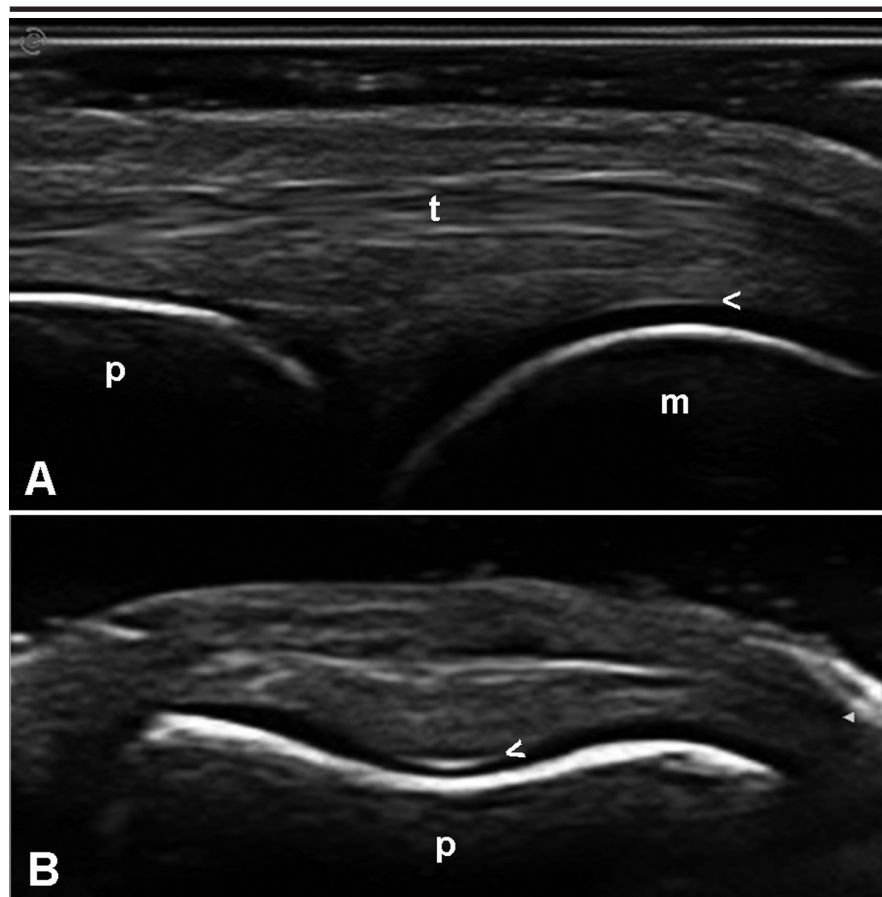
Healthy subject. High-resolution grey-scale ultrasound using a 18 MHz linear probe showing anatomic details less than 1 mm in size. A. Longitudinal dorsal view of the metacarpophalangeal joint in maximal flexion visualizing a subtle anechoic layer of 0.4 mm covering the metacarpal head. B. Transverse dorsal view of the head of the proximal phalanx. The hyaline cartilage is 0.12 mm thick. The arrowheads indicate the chondro-synovial interface appearing as a thin hyperechoic line at the areas of the cartilage surface perpendicular to the ultrasound beam direction. m = metacarpal head; p = proximal phalanx; t = finger extensor tendon.
